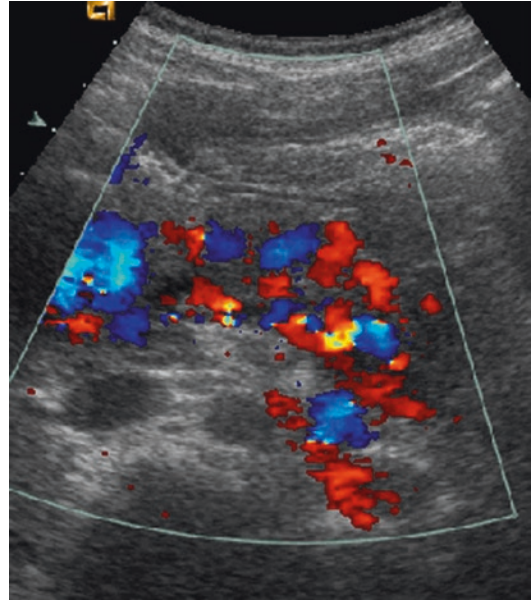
Late complications of AP (12-year-old boy)—US color Doppler follow-up 4 weeks after acute pancreatitis reveals multiple collateral veins around the pancreatic gland secondary to splenic vein thrombosis
